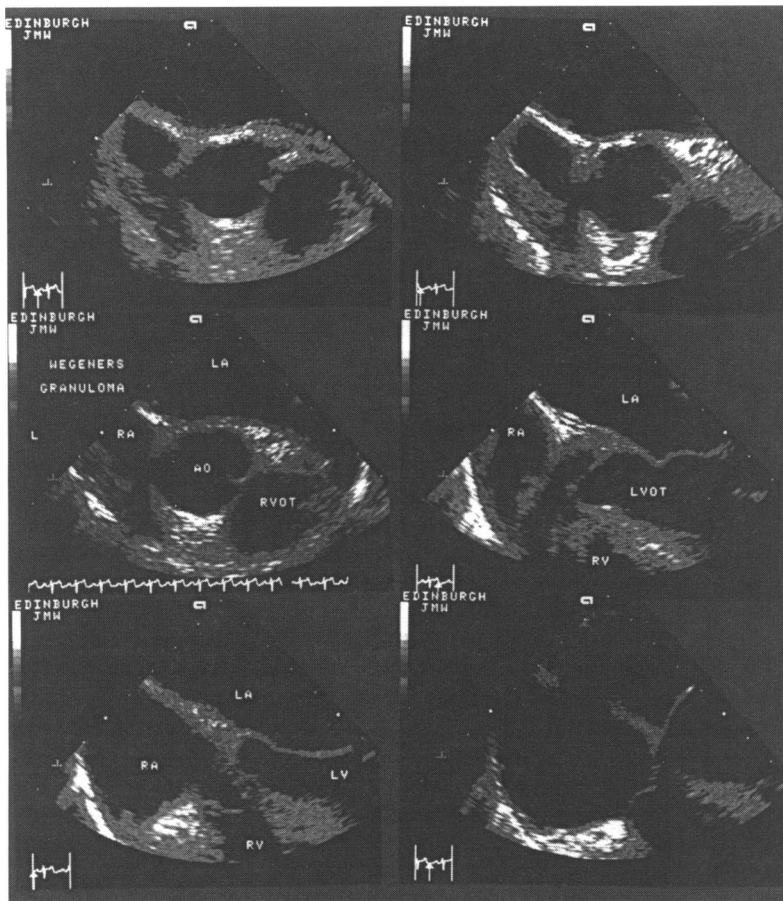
Transverse plane transoesophageal echocardiograms 6 weeks after starting treatment with cyclophosphamide and prednisolone. Upper left panel: the aortic root is cut in transverse section at the level of the left coronary artery. Note that the previous thickening seen in fig 1 is largely absent. Upper right, middle left and middle right panels: sequential sections are demonstrated by introducing the probe further through the aortic valve and into the left ventricular outflow tract. Note that gross thickening of the aortic root and hyperechogenicity are now mostly absent. The mass lesion in the left ventricular outflow tract has resolved. Continuous wave Doppler examination from the apex confirmed normal flow velocities in the left ventricular tract after treatment. Lower left and right panels: the probe was retracted to examine the atrial septum; the previous thickening has largely resolved. These features were considered to indicate resolution of Wegener's granulomatosis from the aortic root and the upper left ventricular outflow tract. LA, left atrium; RA, right atrium; RVOT, right ventricular outflow tract; AO, aorta; RV, right ventricle; LV, left ventricle; LVOT, left ventricular outflow tract.
